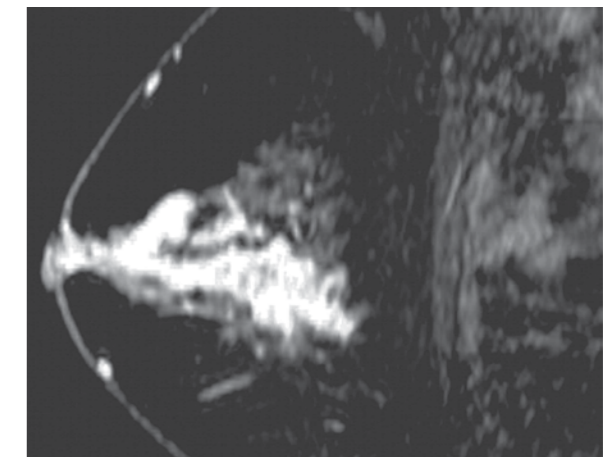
Segmental enhancement on MRI in DCIS Grade 3
